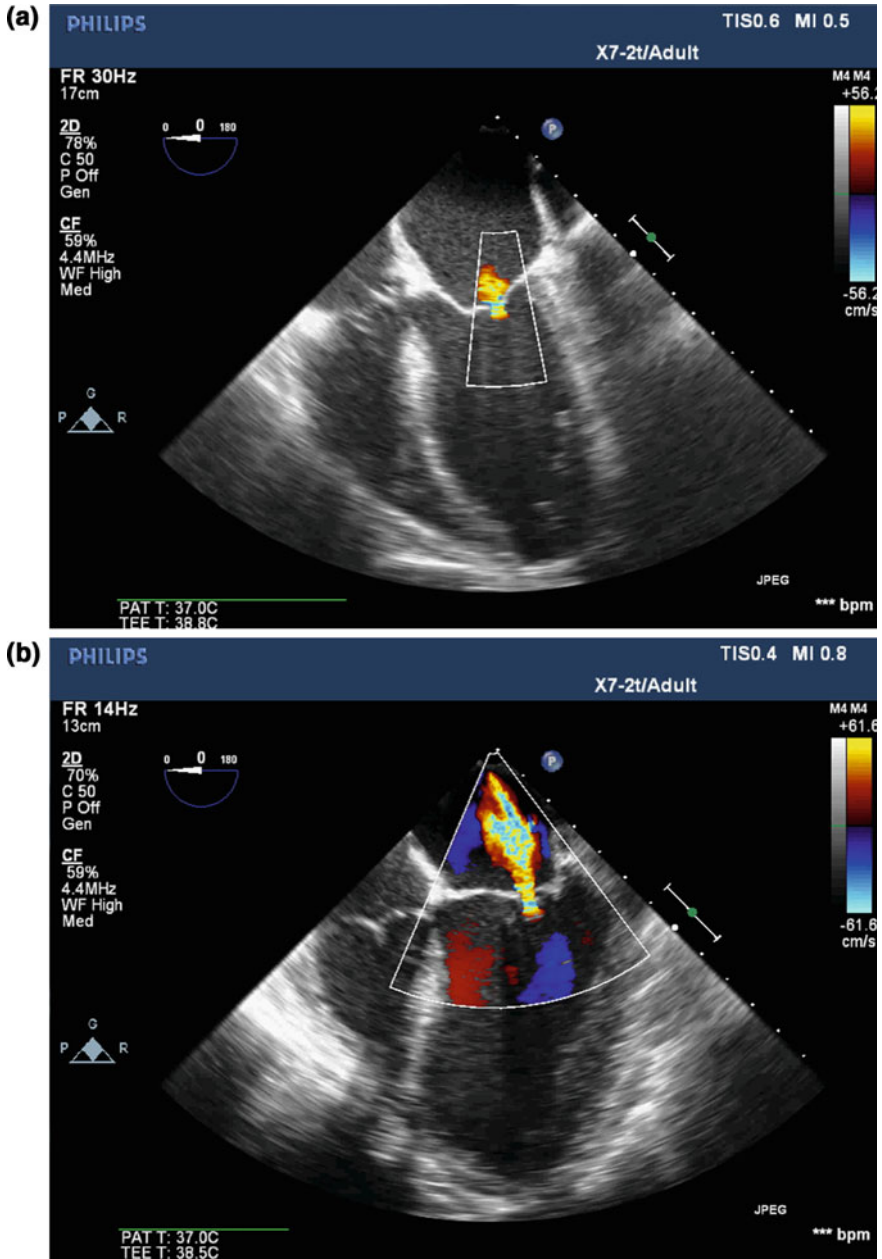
Color flow Doppler showing increasing MR severity. a Trace MR (1+), b mild MR (2+), c moderate MR (3+), d severe MR (4+)
